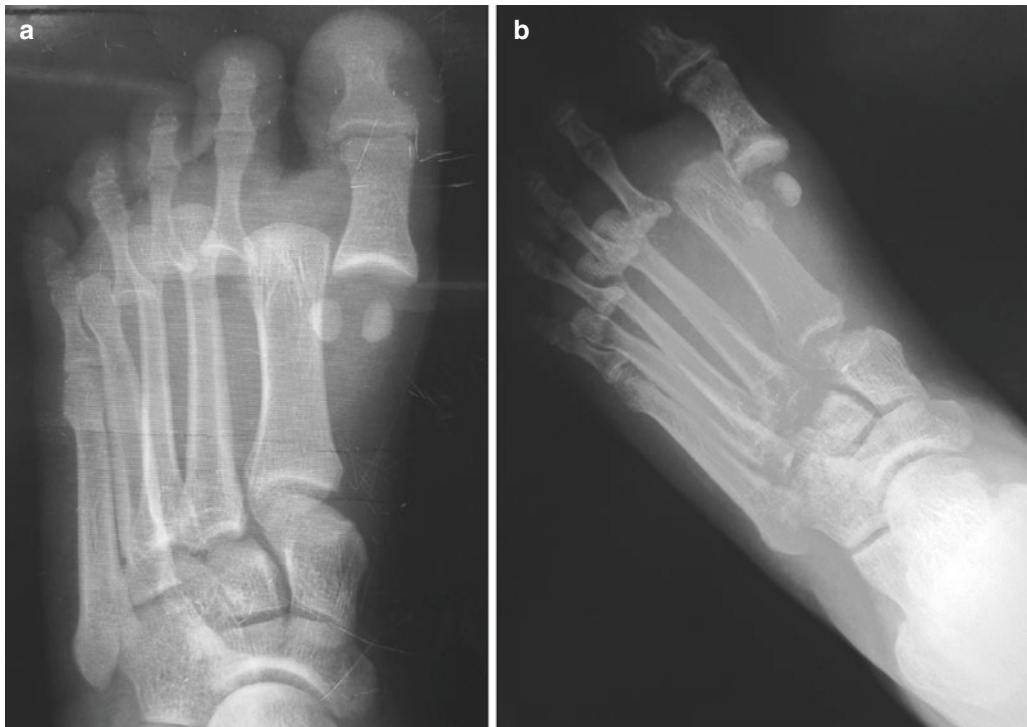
(a) (*left*) X-ray of the foot after being run over by the tire of a car with open plantar-medial dislocations of MT-P joints 1–4. X-ray on the *right* was taken 2 months later. Note periarticular osteoporotic midfoot changes. (b) Appearance of the foot at time of surgery: wound still open but clean, swelling under control, but soft tissues deeply wrinkled and brawny. (c) X-ray post removal of MT heads and realignment of rays
